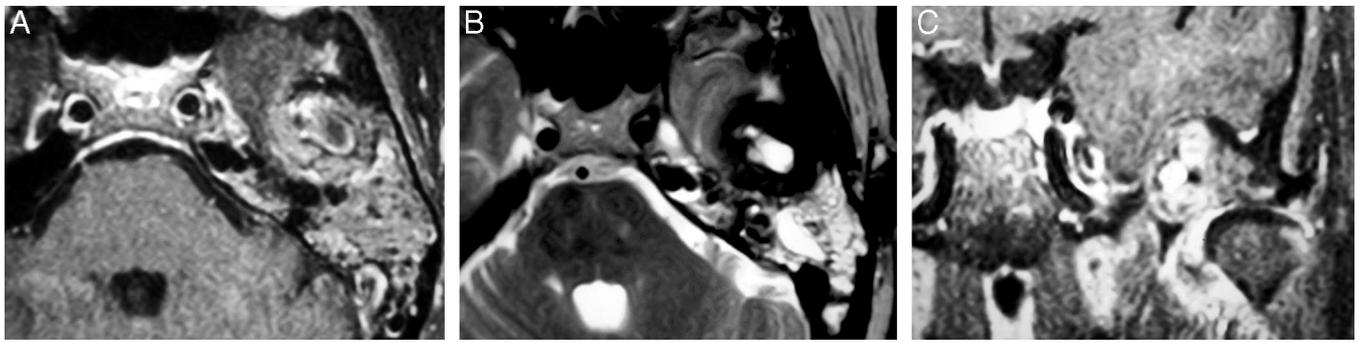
(A) Axial T1-weighted, gadolinium enhanced MRI shows ovoid heterogeneously enhancing mass medial to the glenoid fossa on the floor of the middle cranial fossa. (B) Axial T2-weighted MRI shows hypointense ovoid mass on the middle fossa floor with a markedly hyperintense center, lying anterior to the hyperintense liquid-containing mastoid antrum. (C) Coronal T1-weighted, gadolinium enhanced MRI shows a heterogeneously enhancing rounded mass expanding the floor of the middle fossa in the supra-glenoid region. The mass bulges superiorly, elevating the temporal lobe and inferiorly towards the infratemporal fossa.
